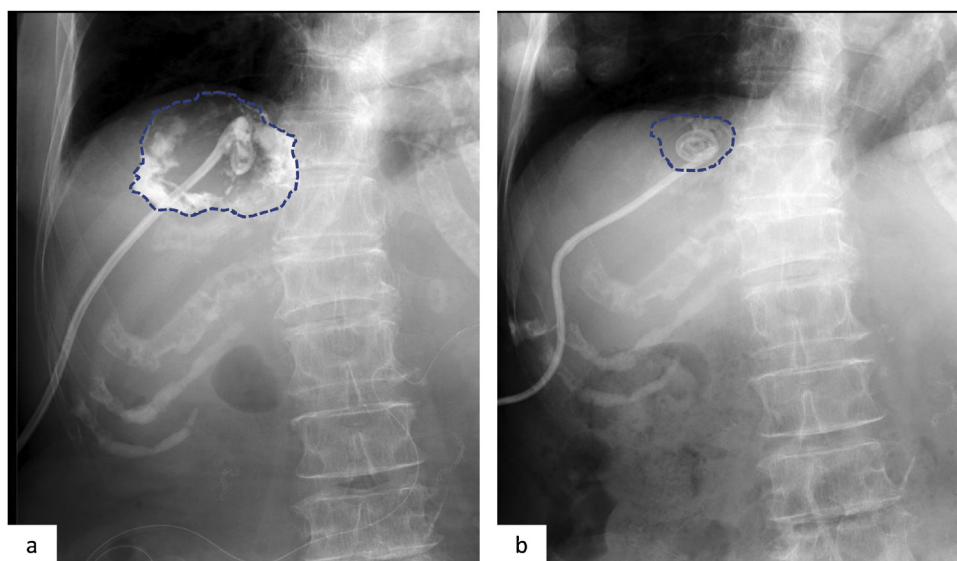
Sclerotherapy using minocycline hydrochloride under radiography.
